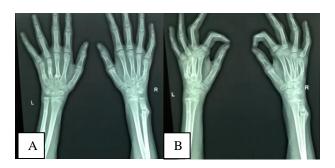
At 6 weeks follow-up, radiographs demonstrating union of fractures (fracture shaft of ulna on both sides, fracture of 3rd, 4th and 5th metacarpals on left side, and fracture of 5th metacarpal on right side).
